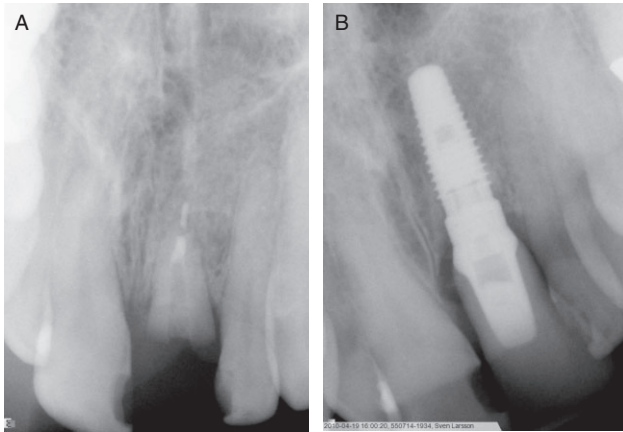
A, Radiograph showing root remnant before extraction and immediate placement of an implant for immediate loading. B, Radiograph showing same site after 7 years of loading.
